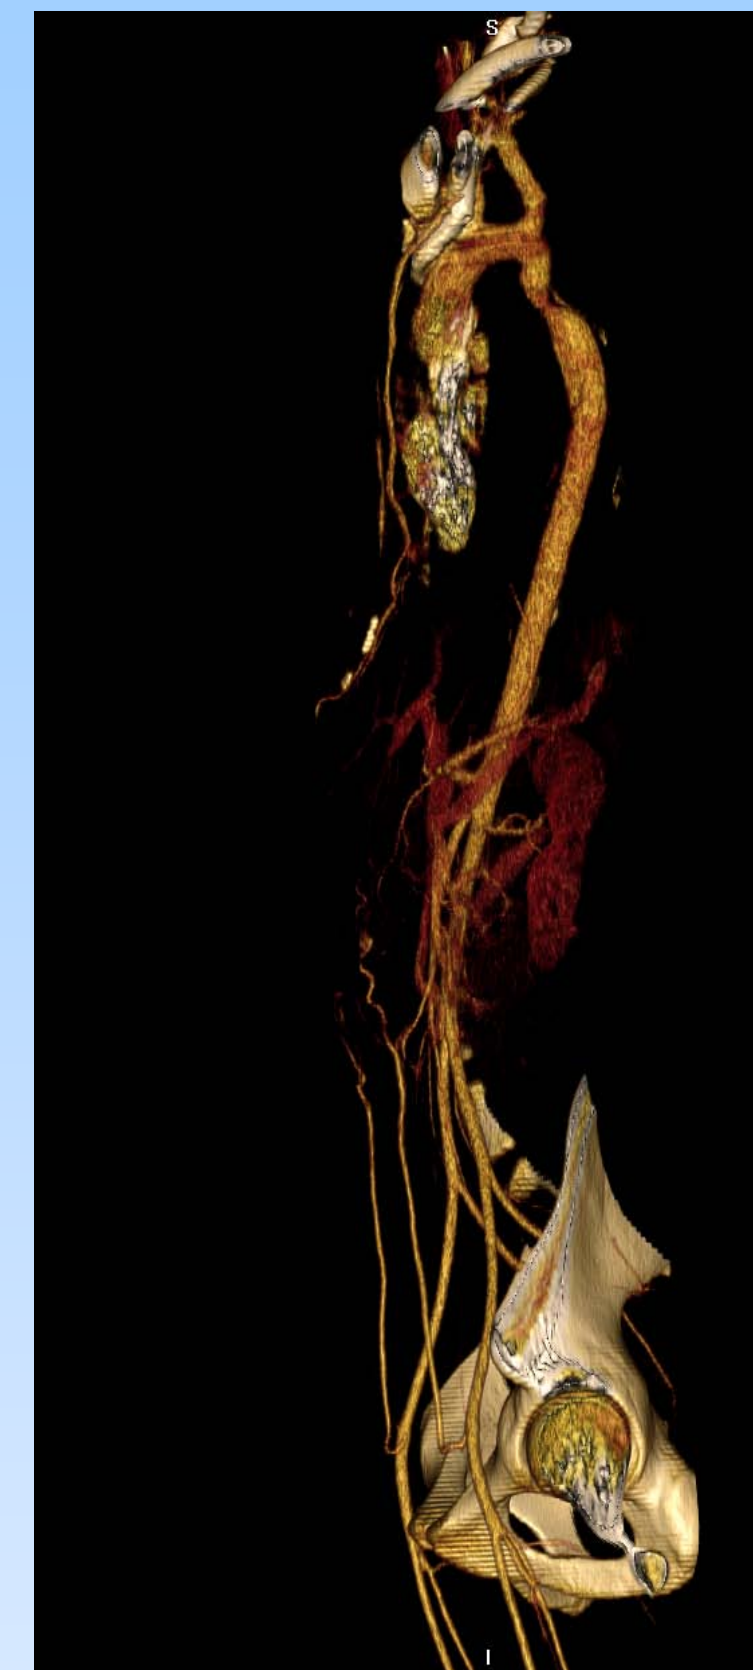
Reconstructed 3-D image from CTA demonstrating full view of ascending aorta, arch, and descending aorta
